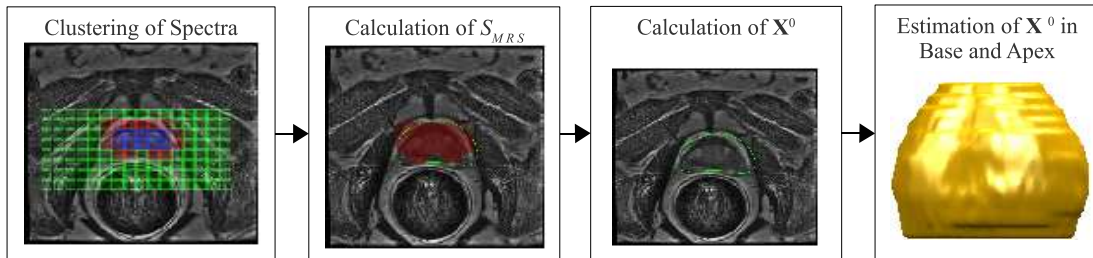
Pathways and modules involving in the MRS-based ASM initialization scheme for prostate segmentation on multi-protocol *in vivo* MRI.
